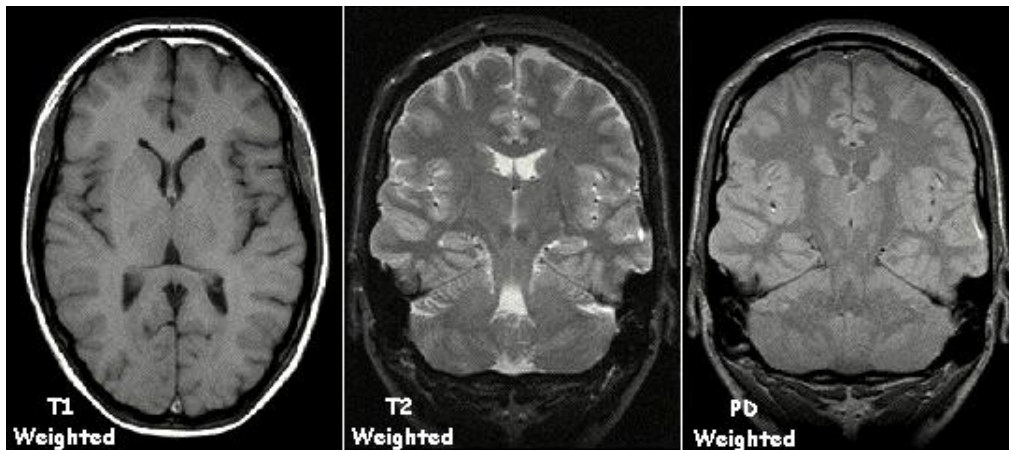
Three types of MR image: the T1 weighted image depicts relatively bright grey matter and dark cerebrospinal fluid; the T2 weighted image highlights the CSF, while the PD (proton-density) weighted image shows little contrast between tissues.[2]
